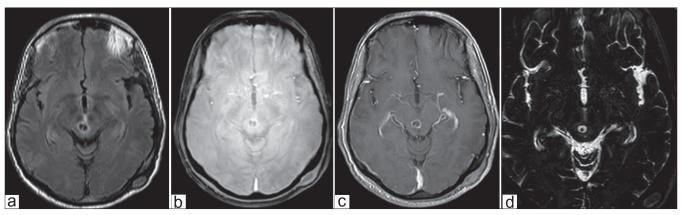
MRI brain (a) T1-weighted sequence showing hyperintense rim with scolex showing, (b) Diffusion-weighted sequence showing scolex within the ring lesion, (c) T1-weighted image with gadolinum enhancement showing contrast enhancing ring and scolex and (d) Constructive Interference Steady state (CISS) 3D sequence showing the cystic lesion
